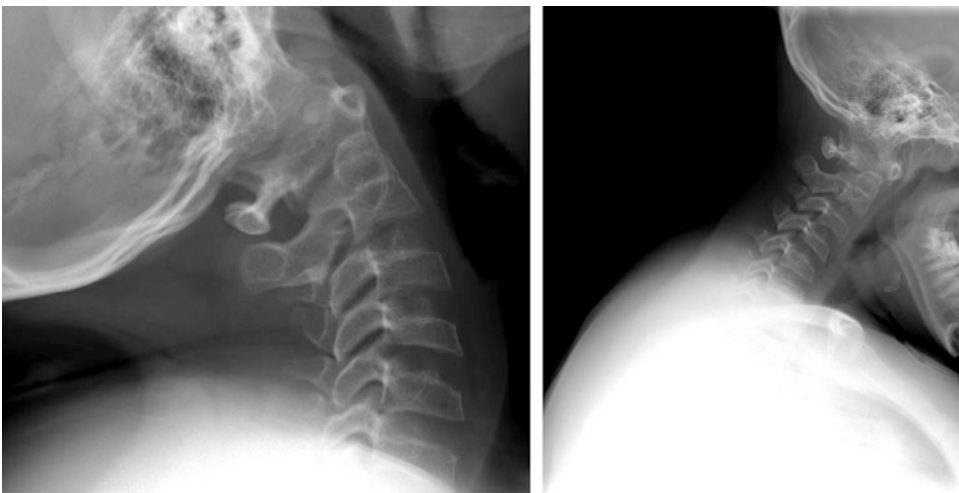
Lateral cervical spine extension and flexion radiographs: os odontoideum associated with C1–C2 instability characterized by displacement of >2 mm of anterior arch of C1 in relation to the odontoid process
